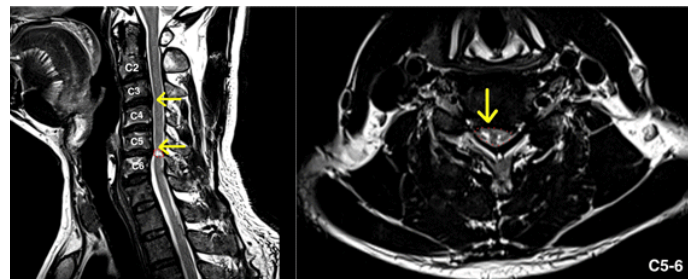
C-spine MRI of Case 2
